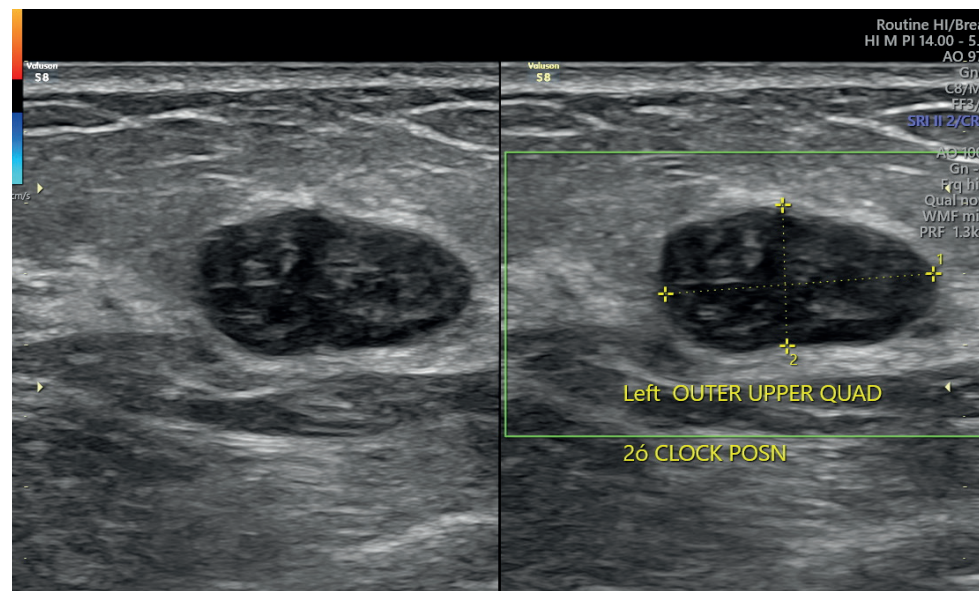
Ultrasound appearance of fibroadenoma with lobulated features; located in the left upper outer quadrant.
